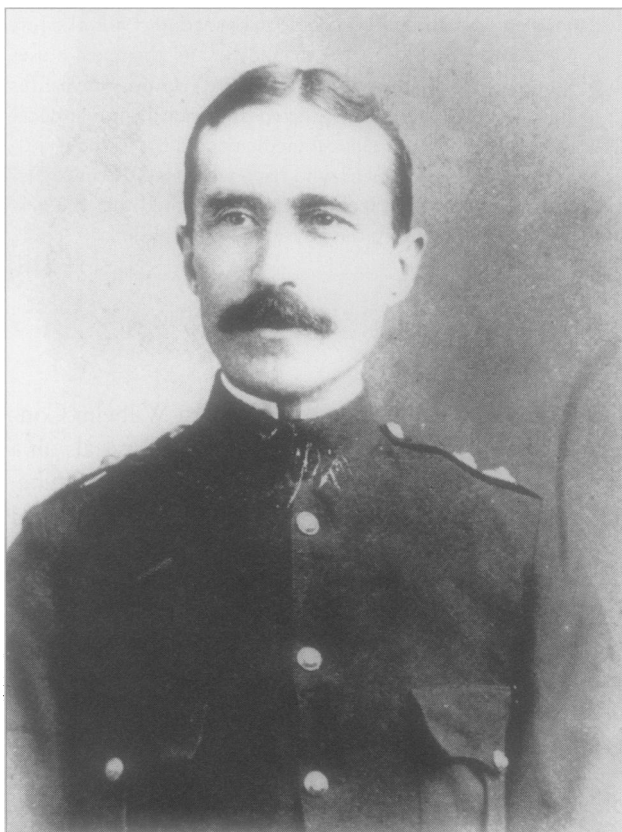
Captain John Bray Cochrane (1860–1946), professor of physics and chemistry at the Royal Military College of Canada, was the first person in Kingston, Ont., to use x-rays. Photo provided courtesy of Massey Library, the Royal Military College of Canada.
